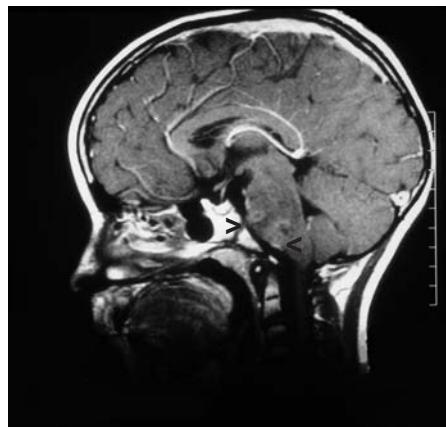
MRI of a malignant brain stem glioblastoma in a 6 year-old child. Arrows indicate foci of necrosis.
